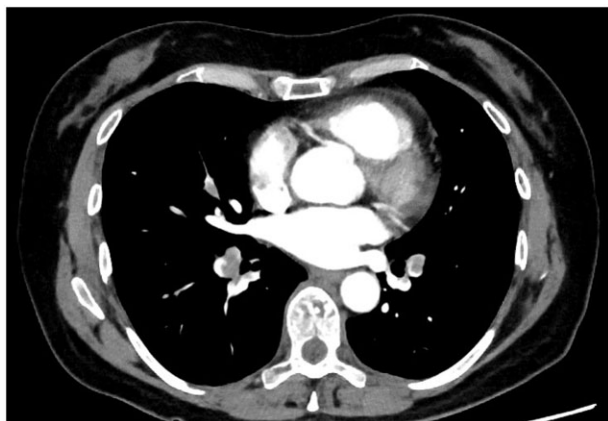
Chest contrast-enhanced CT shows filling defects in multiple branches of the pulmonary artery, which confirms pulmonary embolism.
